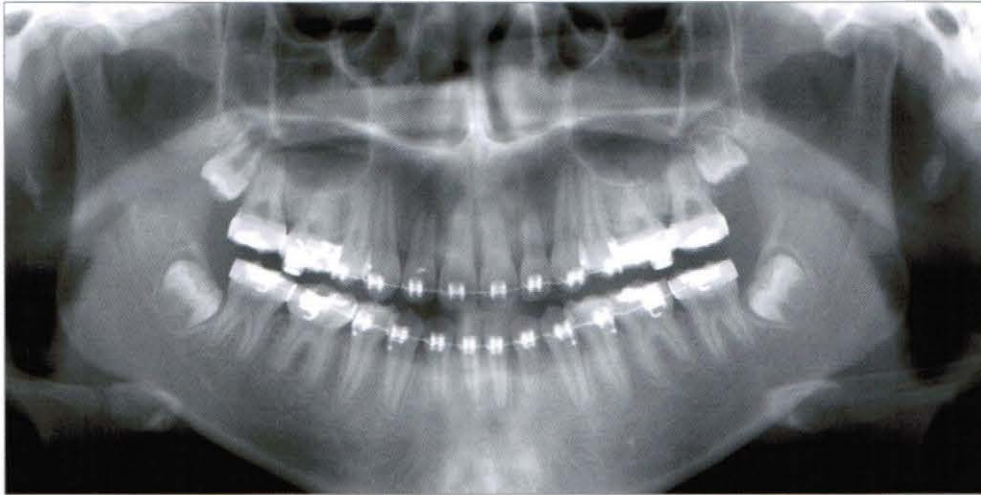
Panoramic radiograph taken at the detailing stage (2004, 10,30)
